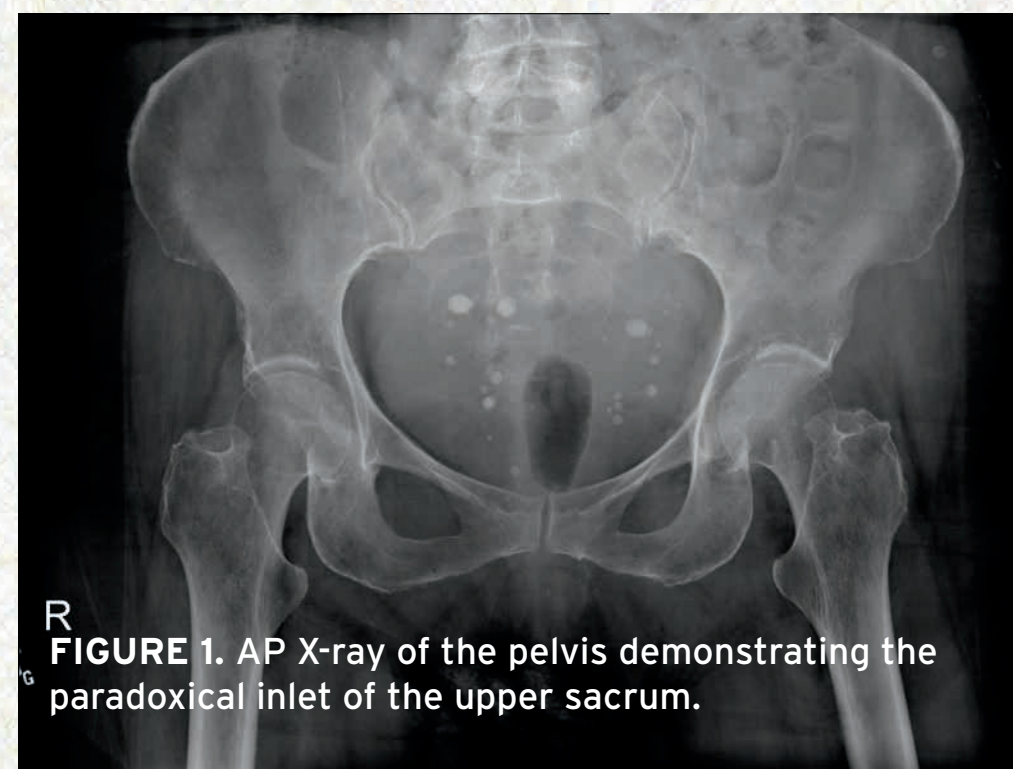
AP X-ray of the pelvis demonstrating the paradoxical inlet of the upper sacrum.
